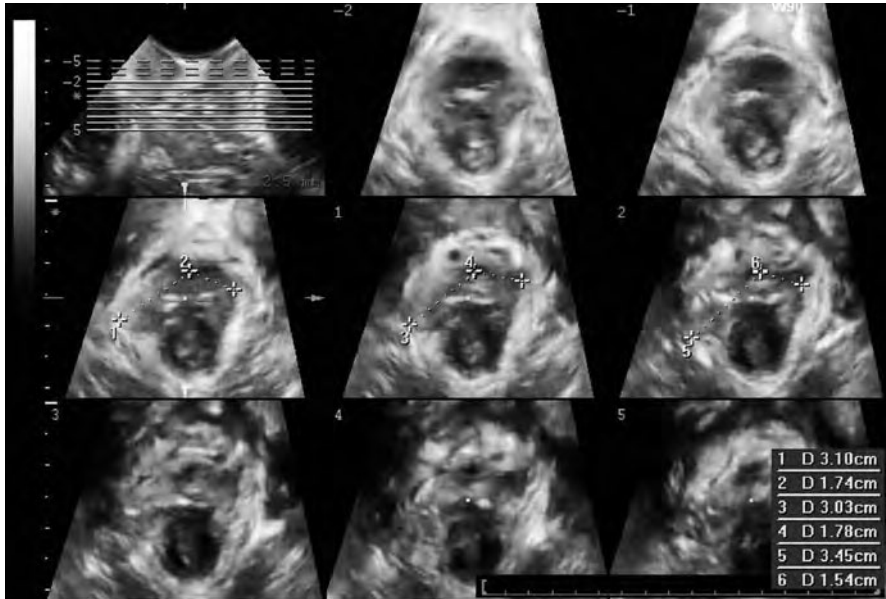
Three-dimensional transperineal ultrasonography. Tomographic ultrasound, showing a right-side levator ani avulsion. (Reproduced from [10], with permission)
